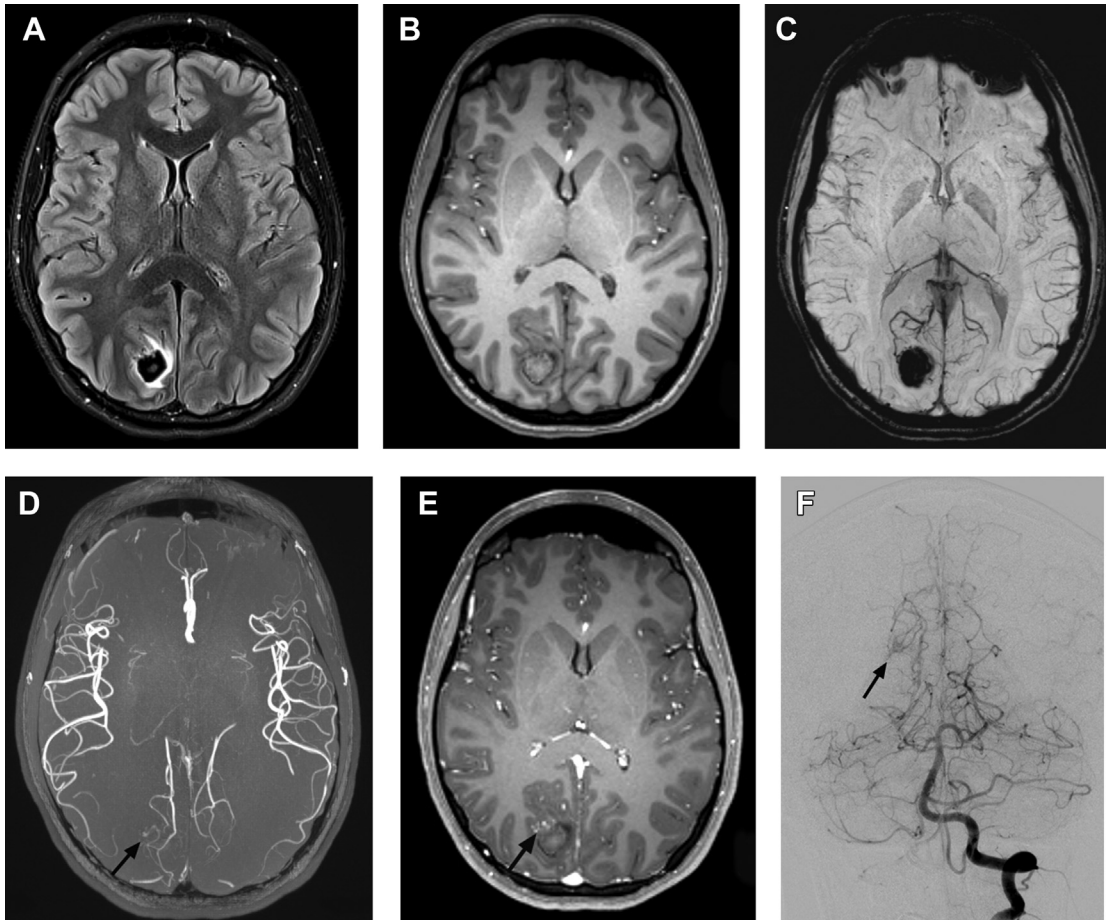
A 15-year-old girl with headache and visual field cut due to an AVM-related hemorrhage. Axial FLAIR (A), 3D T1-weighted gradient echo (B), and SWI (C) MR images demonstrate a small right occipital hematoma with mild surrounding vasogenic edema. Axial time-of-flight MR arteriography maximum intensity projection image (D) and postgadolinium 3D T1-weighted gradient echo (E) demonstrate a small vascular nidus (arrows). (F) Left vertebral artery injection image from a conventional angiogram obtained several months later, after resolution of the hematoma, demonstrates the nidus (arrow). The nidus was angiographically occult at presentation due to compression of the small vessels by the hematoma. The AVM was resected.
